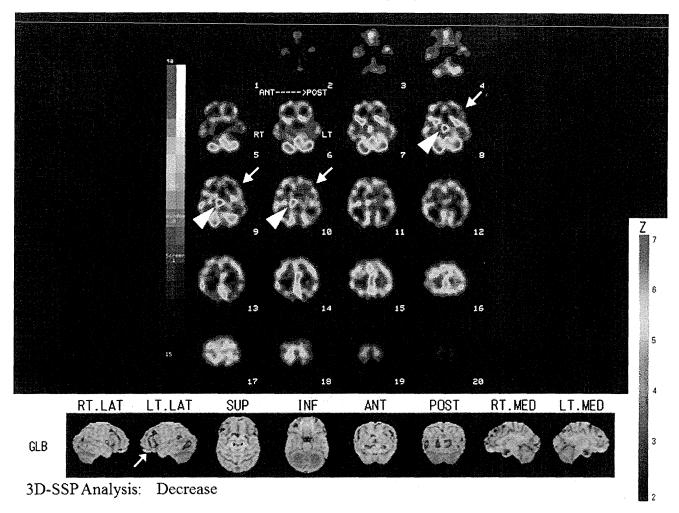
Interictal SPECT with I-123 IMP and 3D-SSP analysis.Interictal SPECT showed hypoperfusion in the left inferior frontal cortex (arrow) and hyperperfusion in the right thalamus (arrowhead). The 3D-SSP analysis emphasizes the hypoperfusion in the left inferior frontal cortex (small arrow).
